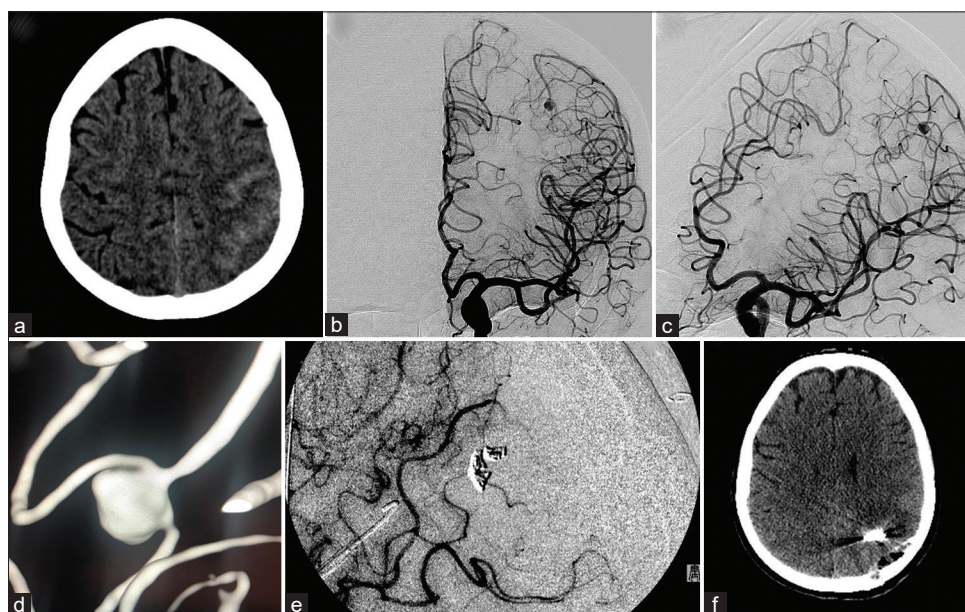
Preoperative, intraoperative, and postoperative imaging. (a) Head computed tomography (CT) at presentation indicating subarachnoid hemorrhage, (b) preoperative angiogram (anteroposterior view), (c) preoperative angiogram (oblique view), (d) preoperative 3D angiography of the neoplastic aneurysm, (e) intraoperative angiogram, (f) postoperative head CT.
